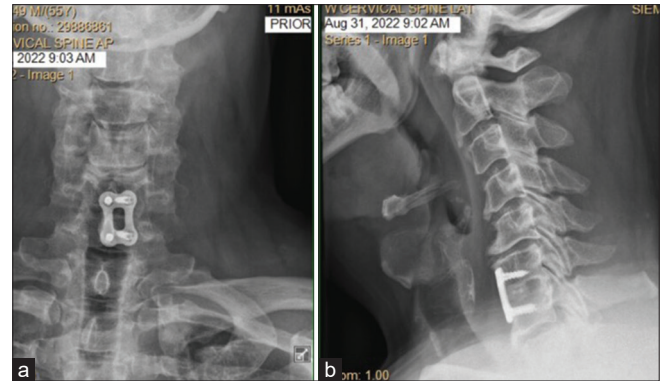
(a) Preoperative Anteroposterior (AP) and (b) Lateral Cervical X-rays. The AP (a) and Lateral (b) preoperative cervical X-rays documented a C67 anterior cervical discectomy and fusion (ACDF) previously performed utilizing an anterior cervical plate/screws with an interbody graft.
